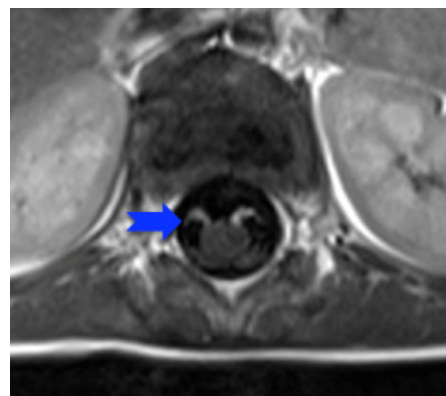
MRI with gadolinium enhanced anterior nerve roots in EV71.
